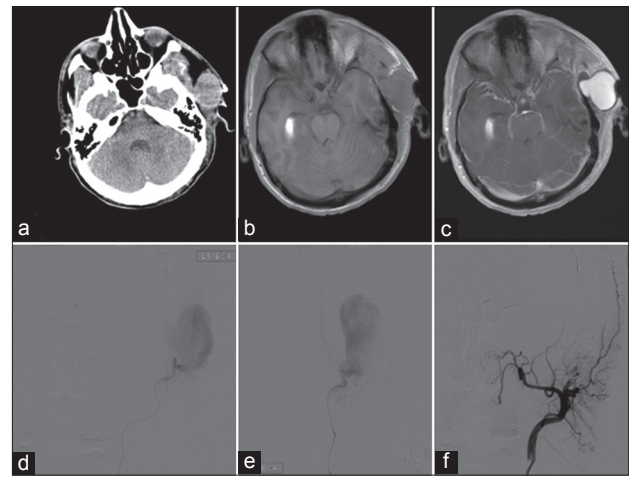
(a) Noncontrast axial CT image revealing a partially hypodense-isodense complex fluid collection superior to the zygoma, 3.6 cm in its greatest dimension. (b) Axial T1-weighted MRI revealing a 3.6 cm hyperintense fluid collection without and (c) with gadolinium, that is homogeneously enhancing. (d) Left selective STA injection, antero-posterior and (e) lateral projections show circular area of contrast blush. (f) Postcoiling angiogram, left ECA injection, antero-posterior projection, shows coils in superficial temporal artery and resolution of contrast blush
